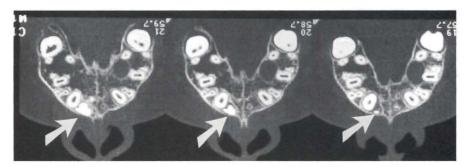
Axial CT scans demonstrate that mesial to tooth #23 a crown-like structure (perhaps of tooth #21) inclined distally can be observed (arrows).
